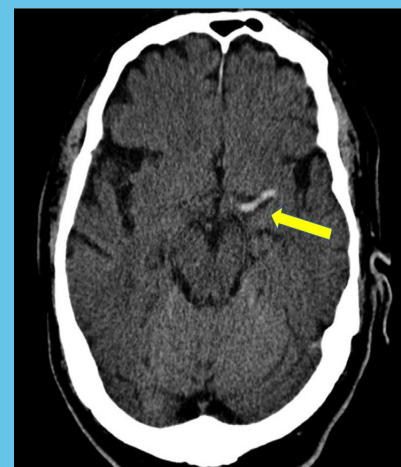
Non-contrast head CT shows a left-sided dense MCA (middle cerebral artery), yellow arrow, in keeping with acute clot within the middle cerebral artery causing the stroke in this patient.
